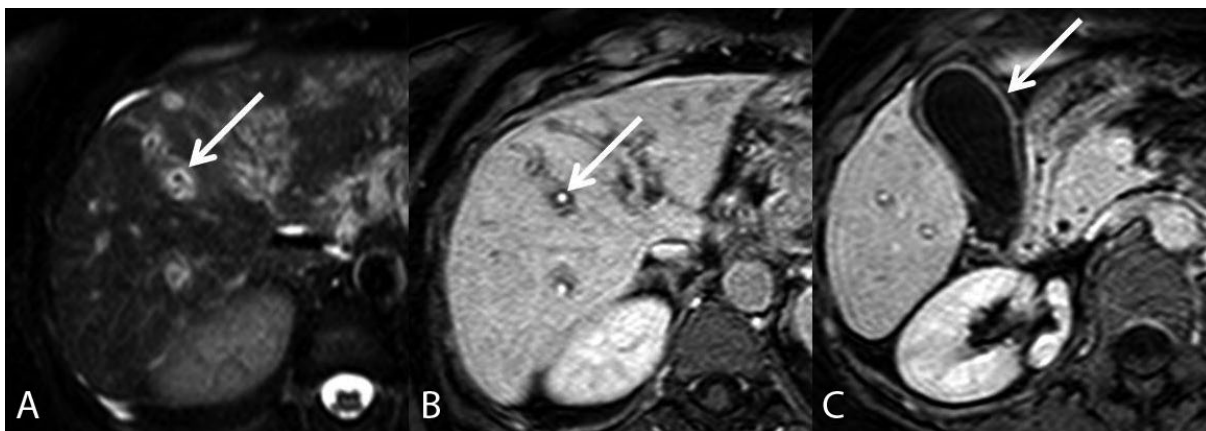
Magnetic resonance images in a 64-year-old woman with acute hepatitis: A and B) Fat-suppressed T2-weighted and portal-venous phase images show periportal edema (arrows). C) Portal-venous phase image shows gallbladder wall thickening (arrow).
